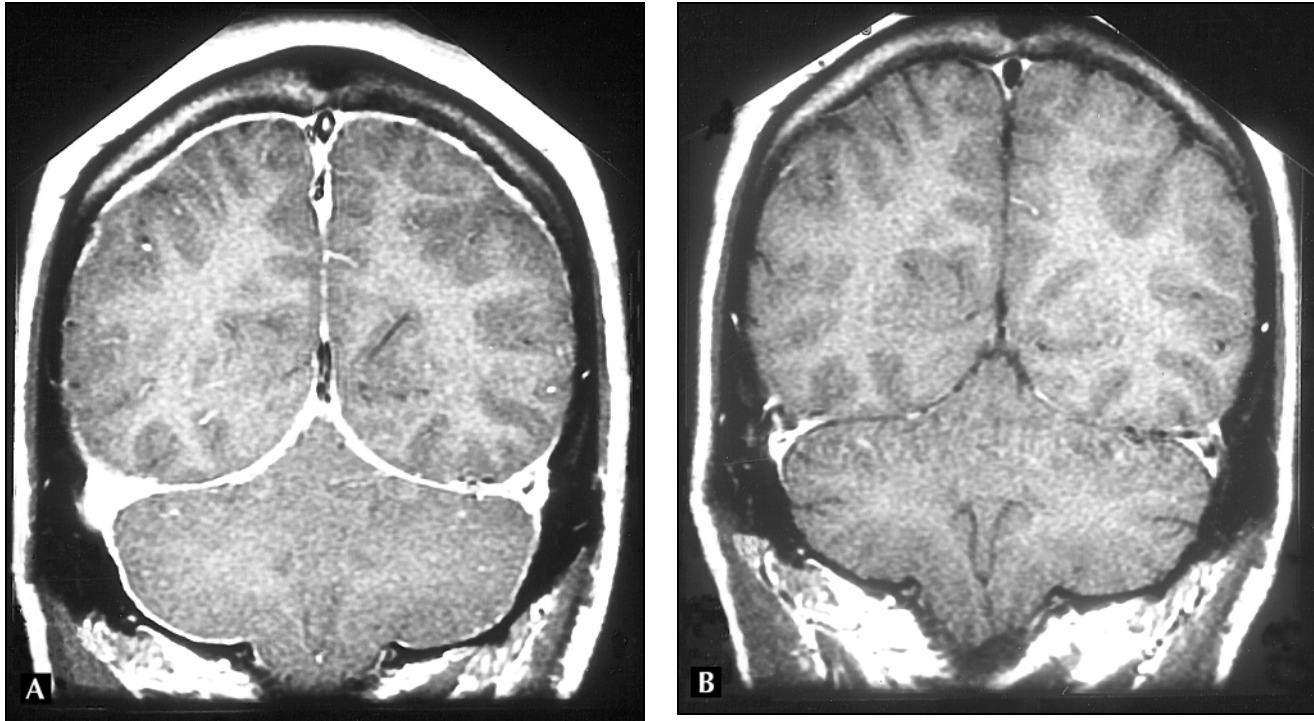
A, MRI coronal views demonstrating contiguous meningeal enhancement involving the convexity, falx, and tentorium. B, Resolution of meningeal enhancement following surgical repair of lumbar cerebrospinal fluid leak. (From Lay *et al.* [18••]; with permission.)
